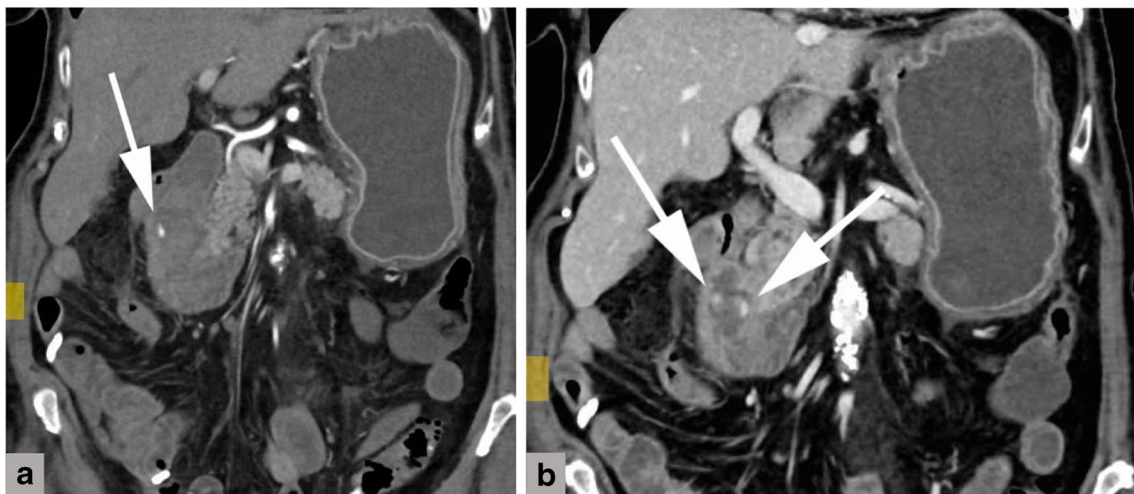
Seventy-five-year-old woman, post-right hemicolectomy and partial duodenectomy who developed post-operative upper GI bleeding. Coronal arterial phase (a) and venous phase (b) IV contrast-enhanced CT
